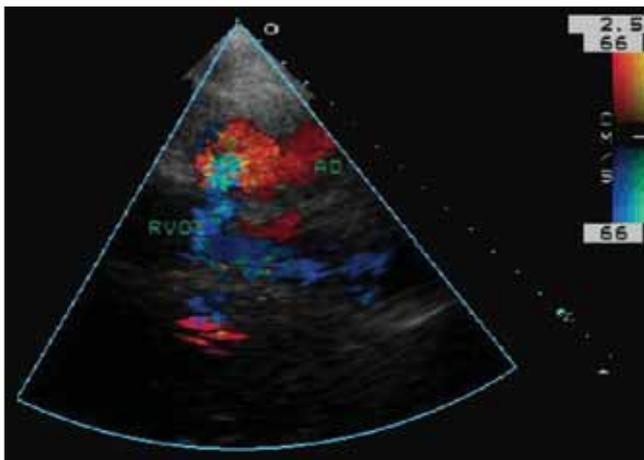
Colour Doppler imaging showing shunt flow from the ascending aorta (AO) into the right ventricular outflow tract (RVOT)
